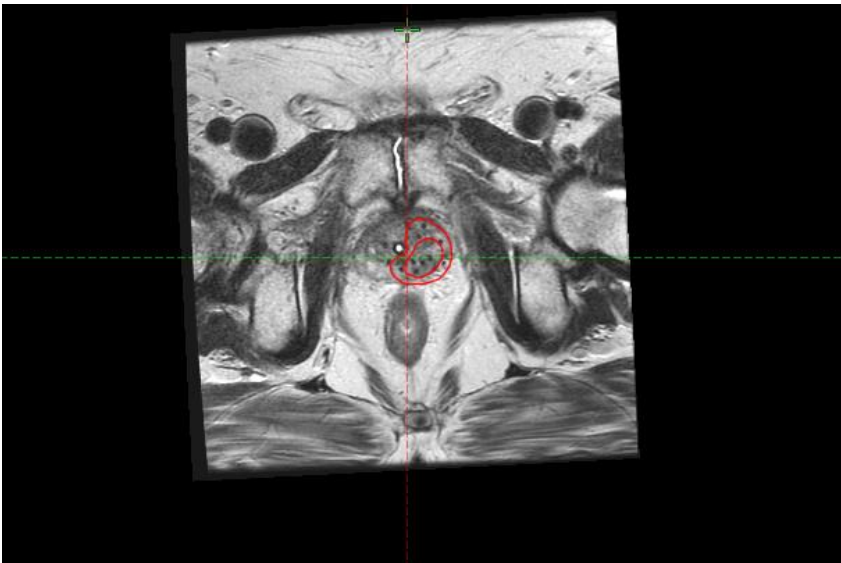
T2 MRI contours with inner red line is the GTV and the outer red line is the CTV
